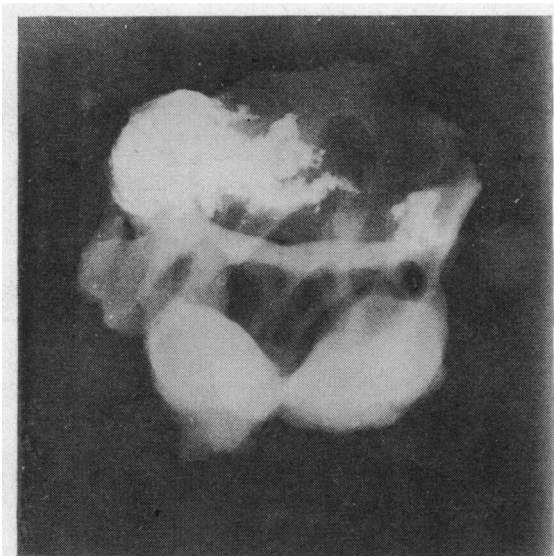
X-ray film of mitral valve apparatus showing heavy and slight calcification in the anterior and posterior leaflets respectively.
